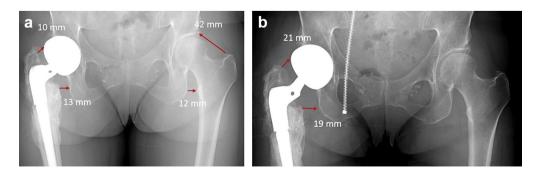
AP pelvis radiographs of a 57-year-old female with trochanteric impingement. (a) The right hip shows a greatly diminished impingement distance of 10 mm compared to 42 mm on the contralateral side. The offset is within 1 mm (13 mm right hip versus 12 mm left hip). (b) Postoperative findings demonstrate an increased right impingement distance of 22 mm accomplished by exchange to a +6mm head from a –6mm head.
